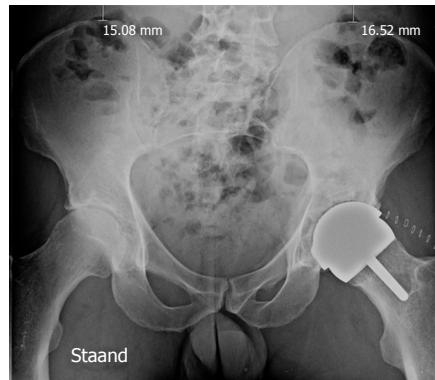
The post-operative X-ray, showed a mismatch between the femoral and the acetabular component diameters.
